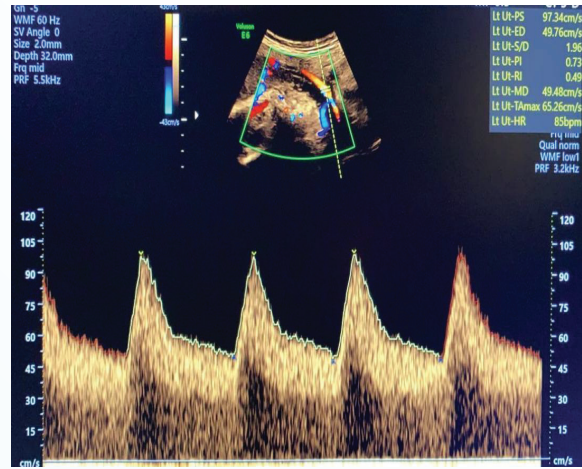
3D rendering image of third trimester fetus, Fig.2 showing Uterine artery Dopplers
